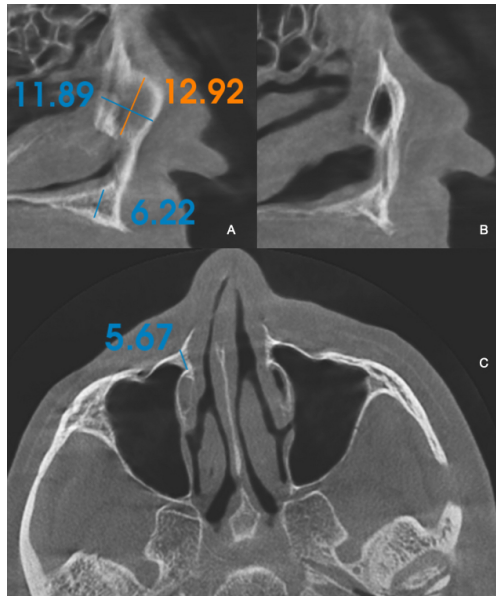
In A: Sagittal image of the computed tomography of the region for installation of the right Transnasal implant, showing adequate bone dimensions; In B: Sagittal image of the computed tomography of the region for the installation of the left Transnasal implant, showing the pneumatization of the maxillary sinus, making the installation of the implant unfeasible; In C: Axial section with the distance between the anterior wall of the frontal process of the right maxilla and the nasolacrimal duct.
